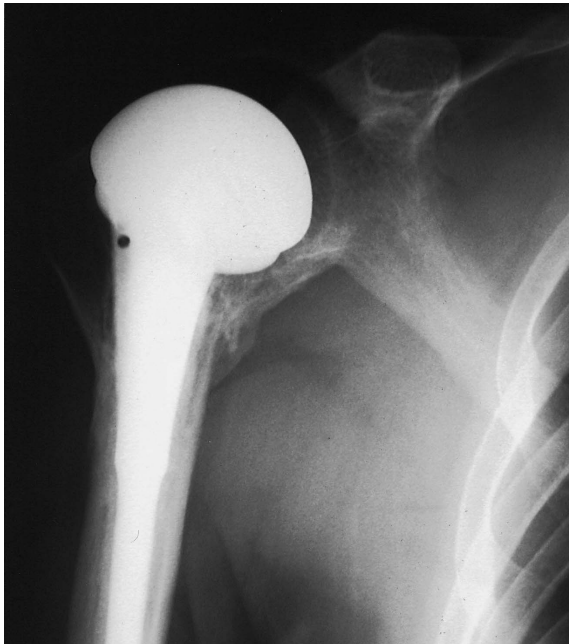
Anteroposterior X-ray of the right shoulder 6 years after surgery shows good position of the prosthesis.
